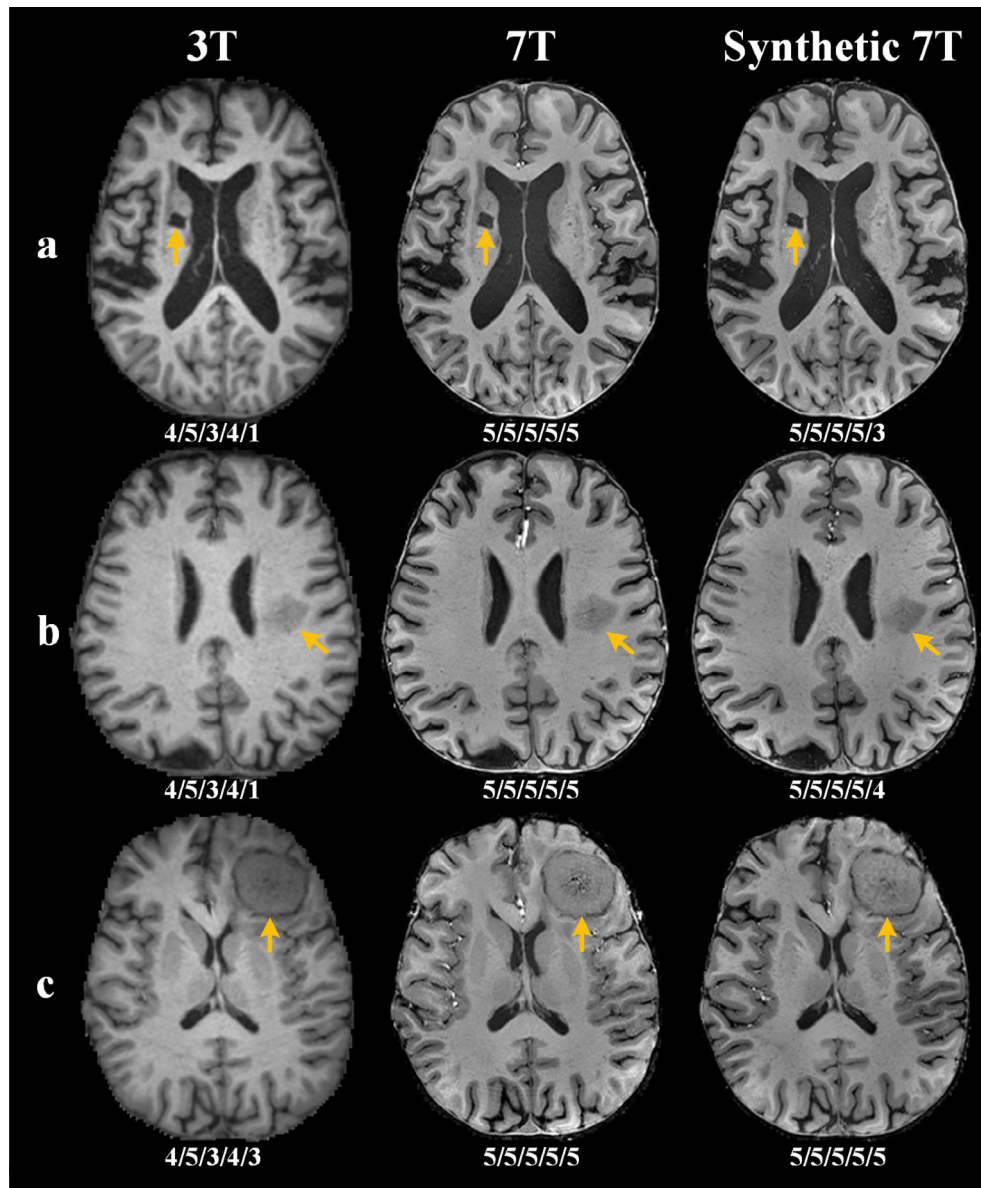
Comparisons of representative 3T, 7T, and synthetic 7T nonenhanced images. (a) T1-weighted images in a 70-year-old man with ischemic cerebrovascular disease. (b) T1-weighted images in a 56-year-old man with left paraventricular lesion. (c) T1-weighted images in a 63-year-old woman with meningioma. The synthetic 7T images provide better sharpness and lesion contrast compared with the 3T images. The golden arrows in (a–c) indicate the lesions of encephalomalacia, demyelination, meningioma, respectively. The image quality scores (overall image quality/artifacts/sharpness/contrast/visualization of vessel) are listed under each image.
